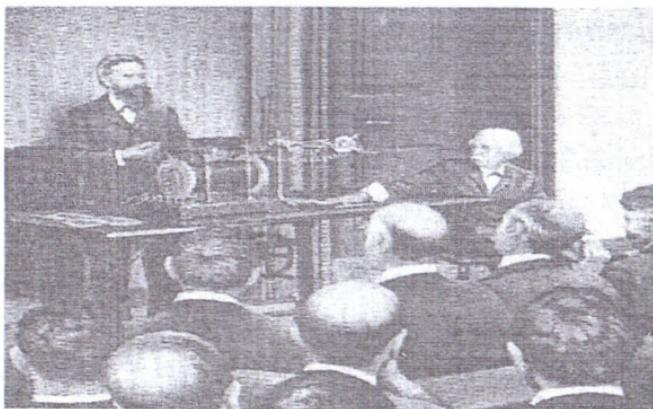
Deadly Spectacle of Open Room Demonstration of newly Discovered X-rays by Roentgen to Members of Society of Physicists
